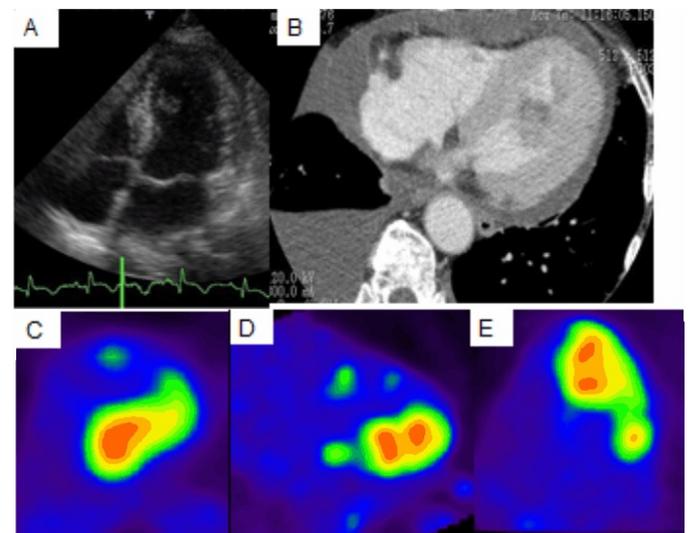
Transthoracic echocardiography obtained eight days after clinical ictus. (A) The apical four-chamber view on B-mode shows an intracardiac mass close to the apex, (B) Contrast-enhanced thoracic CT obtained 13 days after admission demonstrates a low-density mass located in the left ventricle, Cardiac 18F-FDG PET/CT in a fasting state in corresponding short-axis, (C) Vertical long-axis, (D) Horizontal long-axis, and (E) Slices showing abnormal increased uptake in the inferior wall close to the apex. Maximum standardized uptake value (SUVmax) was 10.14 g/mL. Imaging results are consistent with myocardial metastasis
